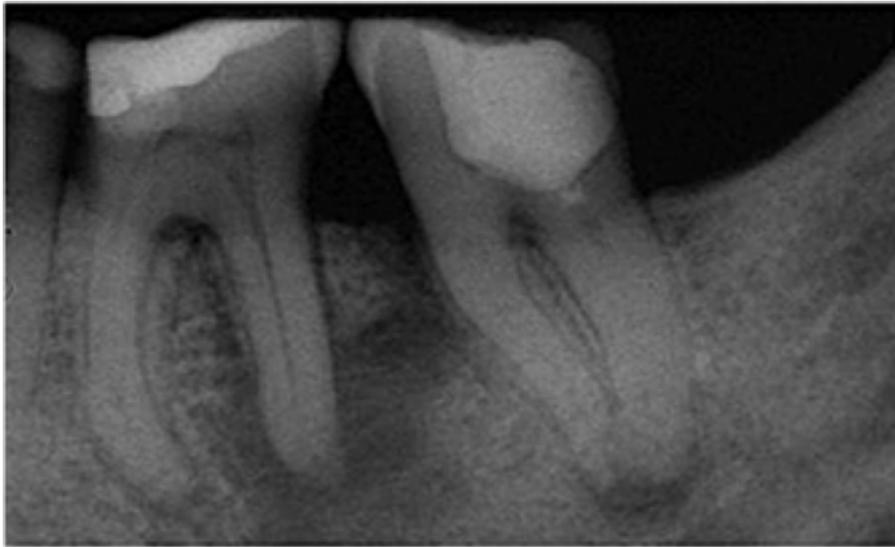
Pre-operative X-ray of teeth 3.6 and 3.7.
